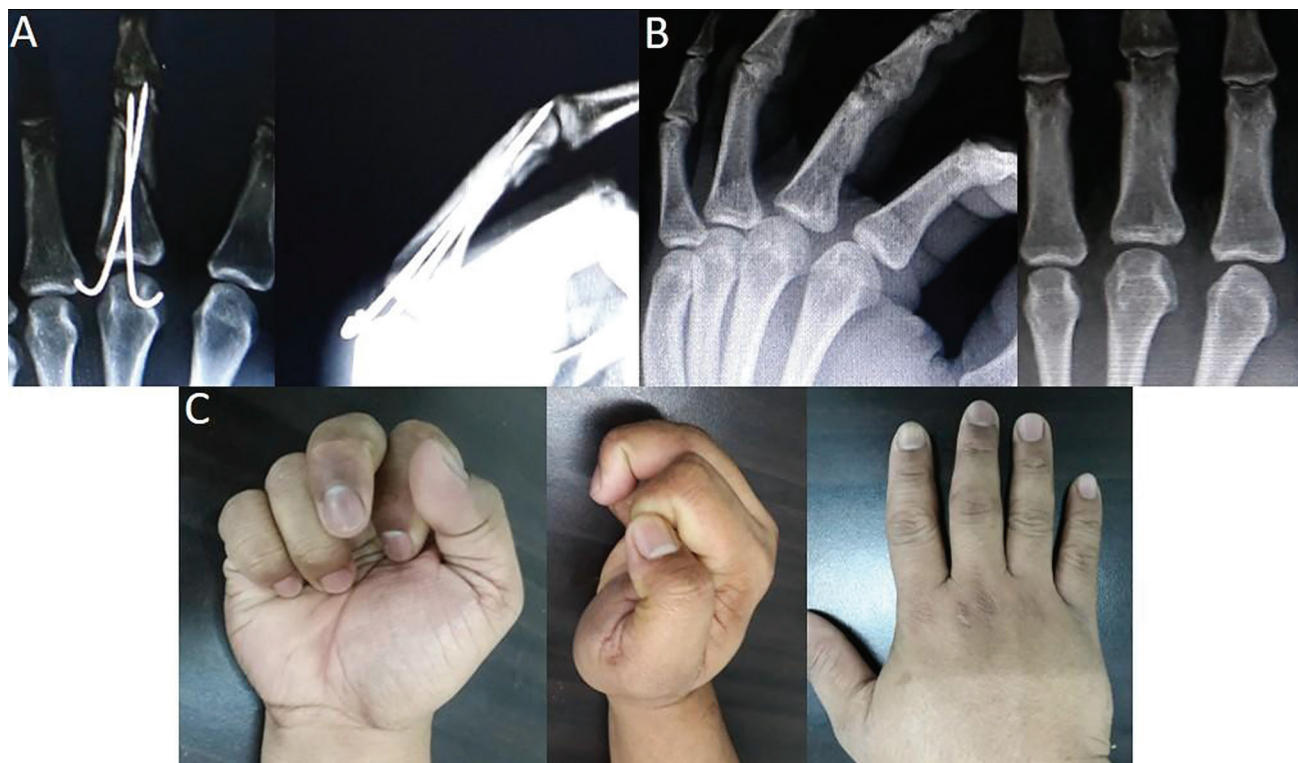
Patient 12 with malrotation noted at the final follow up. Immediate post-operative radiograph (A), radiograph at final follow-up (B), range of motion at final follow-up showing malrotation of middle finger (C).
